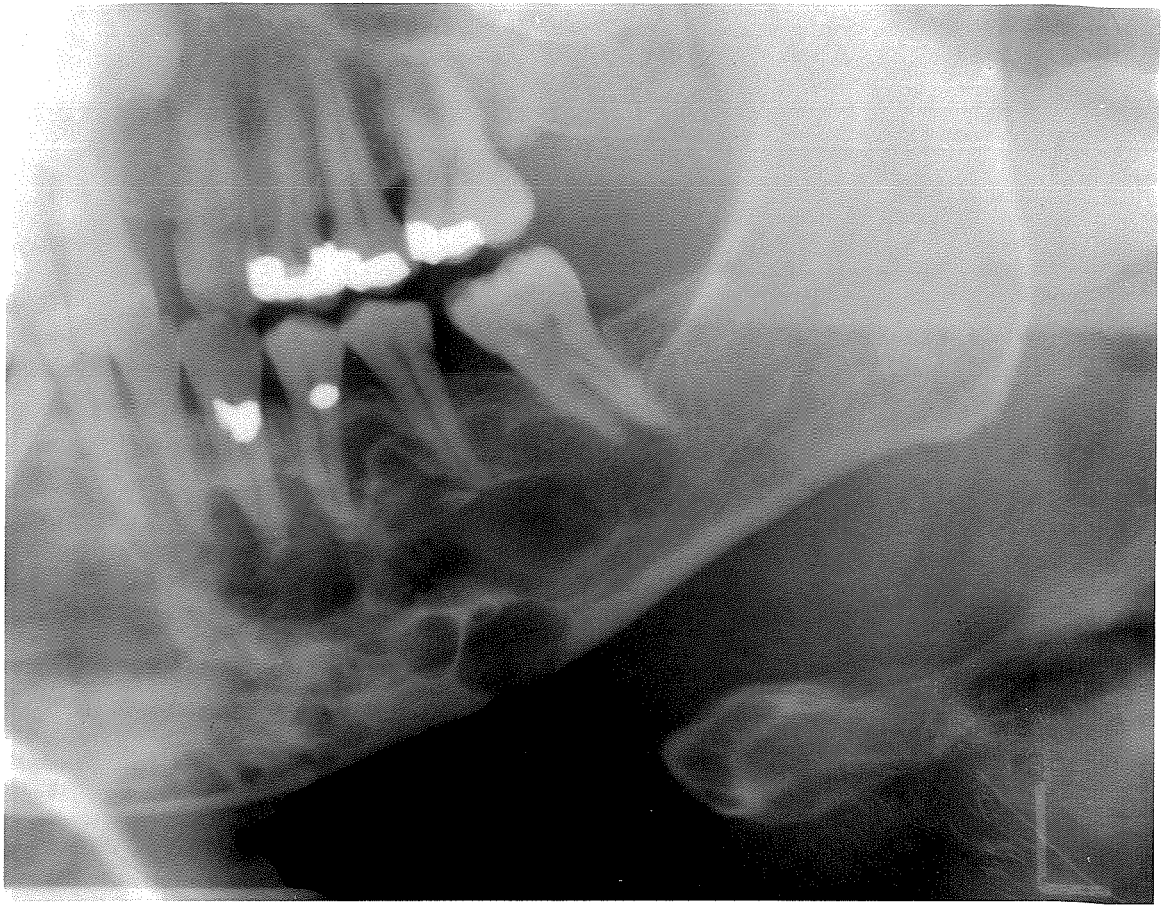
Radiograph of a multilocular keratocyst. The multilocularity was confirmed at operation.
